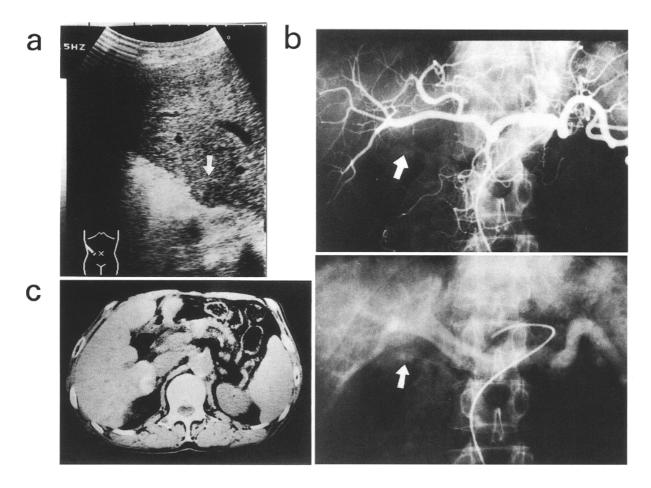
a Abdominal ultrasonography revealed a hypoechoic mass in the posterior segment of the right hepatic lobe (*arrow*). b Hepatic angiography showed a hypervascular nature of the S6 lesion in the arterial phase (*top*, *arrow*) and a tumor
